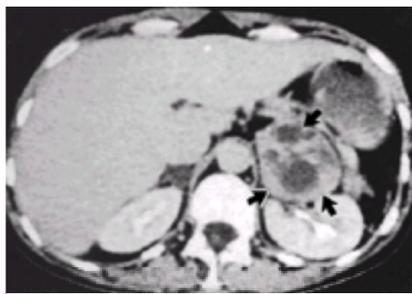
Computed tomographic scan of a 40-year-old woman with a large left adrenal pheochromocytoma outlined by the arrows. Note the multiple cystic areas within the tumor.
